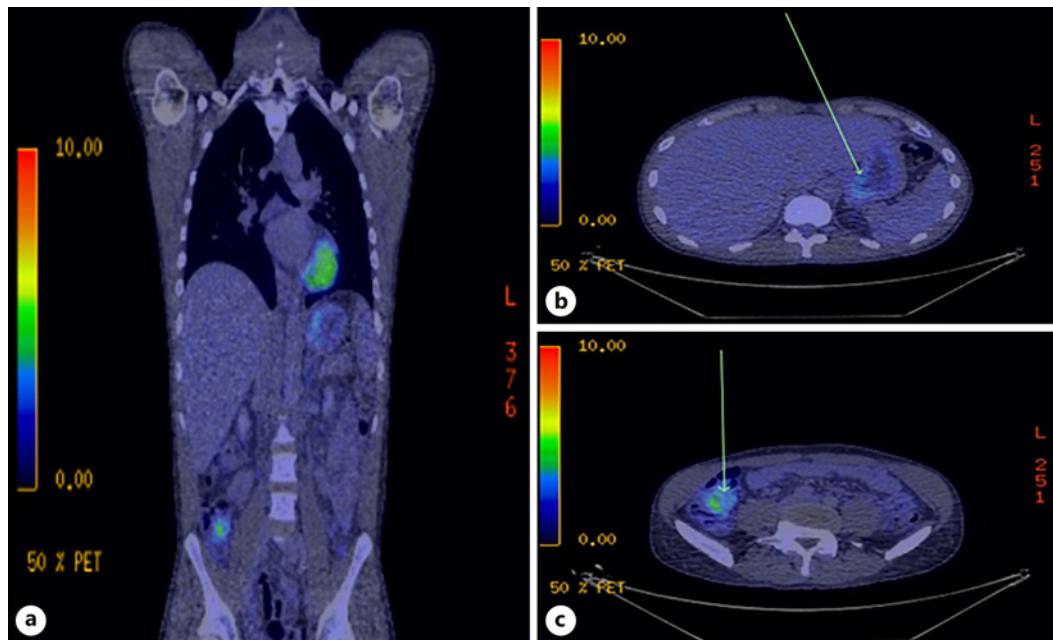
FDG-PET scan on admission. a Coronal section showing mildly increased uptake in the stomach and caecum. b Axial section in the upper abdomen shows increased stomach wall uptake. c Axial section in the lower abdomen shows increased caecum uptake.
